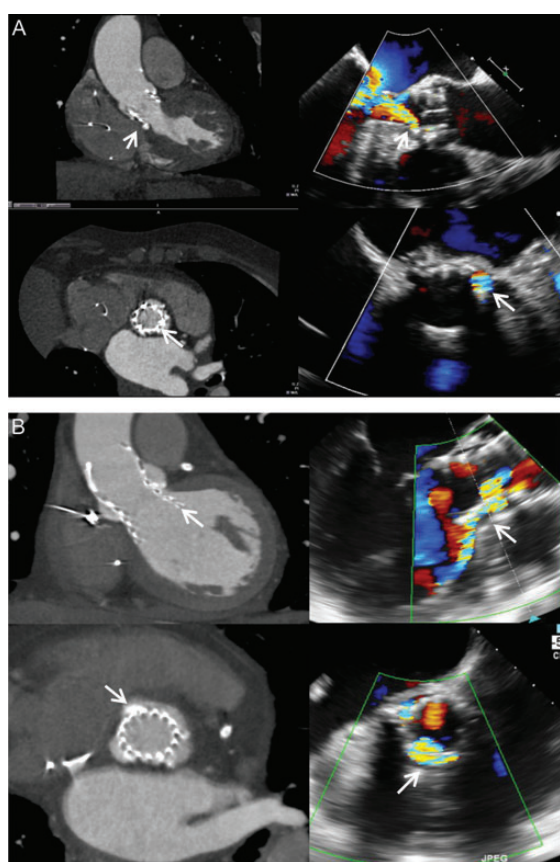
Pathophysiological factors determining paravalvular aortic regurgitation. (A) Example of a patient with mild paravalvular aortic regurgitation at the level of the hinge point with the membranous interventricular septum (arrow). The multi-detector row computed tomography shows a bulky calcification at this level (arrow). The short-axis view shows mild paravalvular aortic regurgitation at the level of the left coronary cusp. Please note on the multi-detector row computed tomography the presence of calcifications at this level surrounding the prosthetic frame (arrow). (B) Deep implantation of a self-expandable transcatheter aortic valve causing significant paravalvular aortic regurgitation (arrow). The multi-detector row computed tomography permits accurate assessment of the deployment of the valve. In addition, there is a paravalvular regurgitant jet originating at the level of the right coronary cusp. The multi-detector row computed tomography shows the presence of a bulky calcified right coronary cusp pushed away following valve deployment (arrow).
